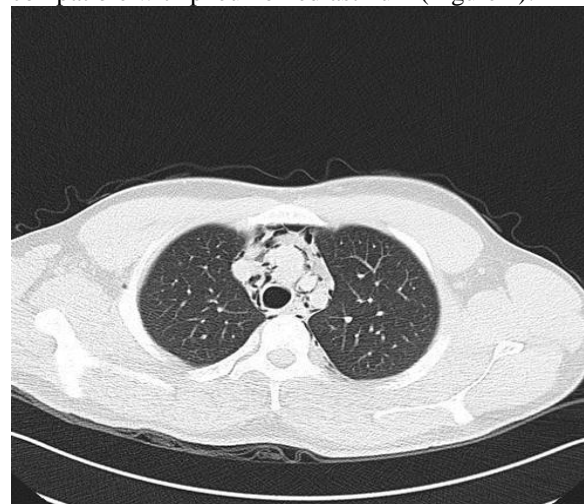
The patient's computed tomography image was compatible with pneumomediastinum.
